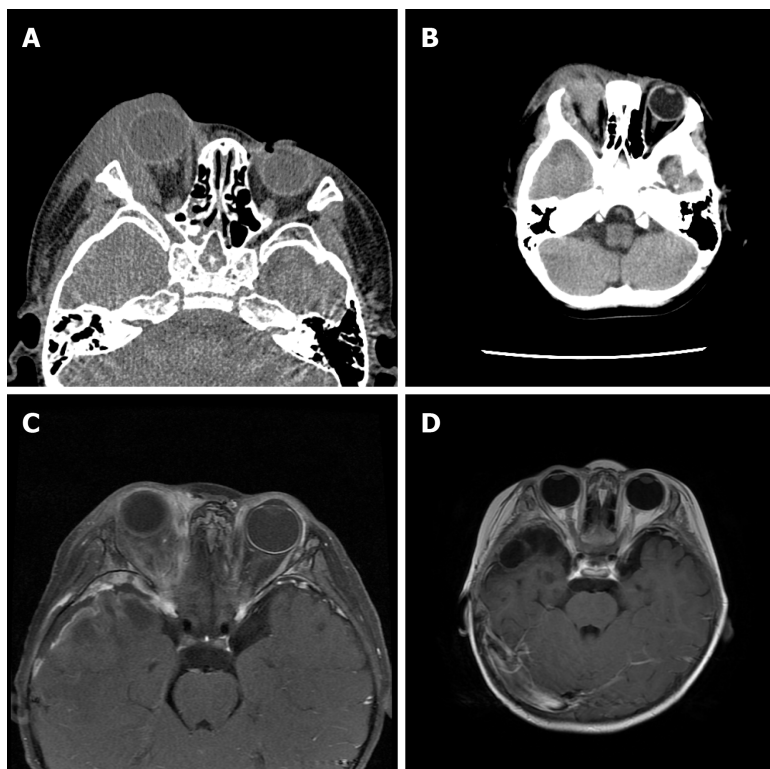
Imaging examinations. A: Eyelid computed tomography (CT) at admission. A soft tissue mass in the right lateral eyelid muscle was noted; B: CT scan of the head after surgery. The lesion range had increased, involving the temporal lobe; C: Enhanced magnetic resonance imaging (MRI) of the eyelid after the first chemotherapy. The right eyelid and its surrounding space-occupying lesion as well as abnormal signal in the right temporal lobe were visible; D: Brain enhanced MRI after treatment. The original lesion was significantly reduced and disappeared.
